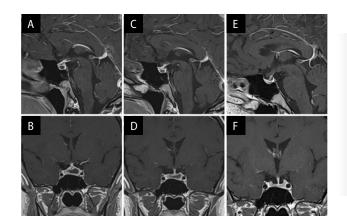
Resonance magnetic imaging (MRI) of the pituitary gland, T1-weighted images after contrast agent administration in sagittal (A, C, E) and frontal sections (B, D, F). AB. First examination. A heterogeneous lesion measuring 9 mm (anterior-posterior [ap]) \times 9 mm (height) \times 21 mm (transverse) with thick rim contrast enhancement at its periphery; thickening of the pituitary stalk to 4.5 mm and altered hypothalamic signal. BC. After 3 weeks of steroid treatment. The heterogeneous lesion within the sella turcica has decreased to 6 mm (ap) \times 5.5 mm (height) \times 19 mm (transverse); thickening of the pituitary stalk to 4 mm; thick rim contrast enhancement around the periphery of the lesion. EF. After 2 months of steroid treatment. Further marked regression of the lesion within the pituitary, now slit-like, is difficult to measure; the pituitary stalk is not thickened, with slightly uneven outlines
